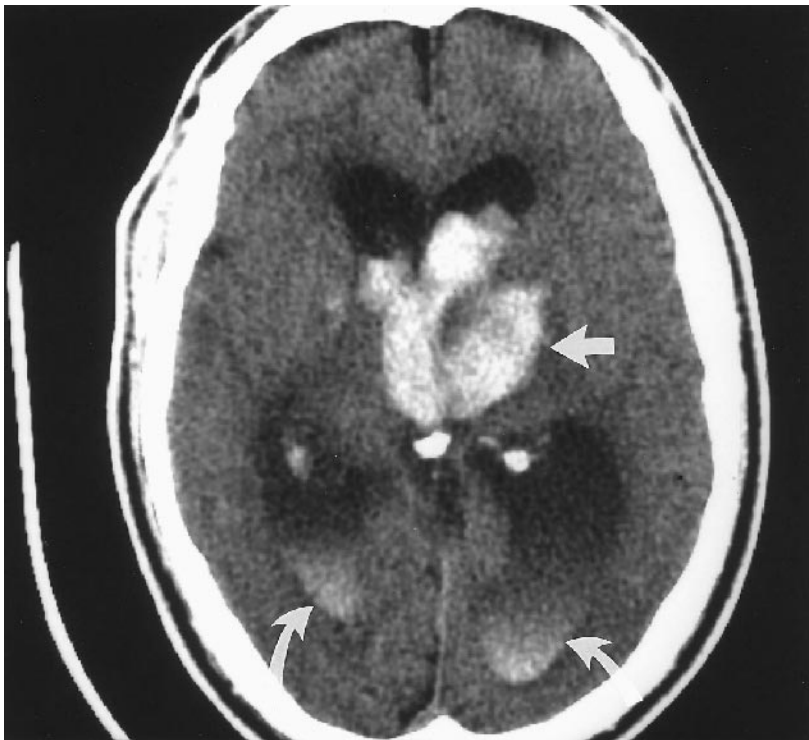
Hypertensive hemorrhage. Axial CT scan at the level of the third ventricle shows acute hypertensive hemorrhage in the left side of the thalamus (arrow), which has broken through into the third ventricle with blood seen layering in the occipital horns of the lateral ventricles (curved arrows).
